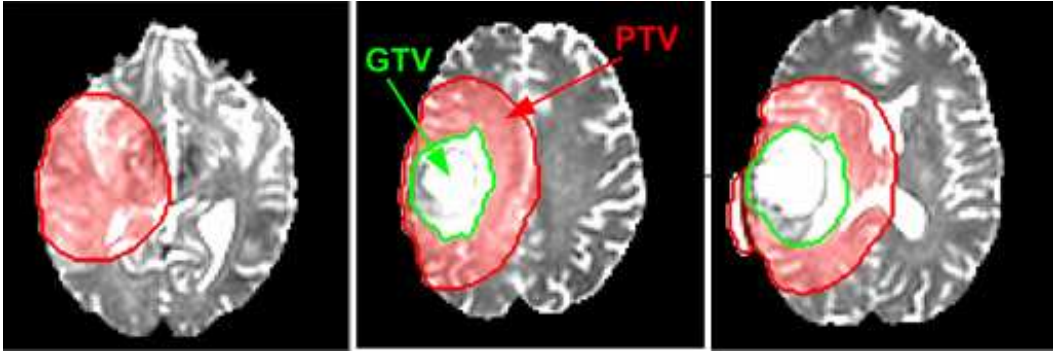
Gross Tumor Volume and planning Target Volume. Slices from an MRI T2 scan showing the gross tumor volume (GTV) in green, which together with the 2cm margin forms the planning target volume (PTV) to be radiated. The PTV is about 500cm^3 , representing 27% of the total brain and about 4 times more than the visible GTV.
